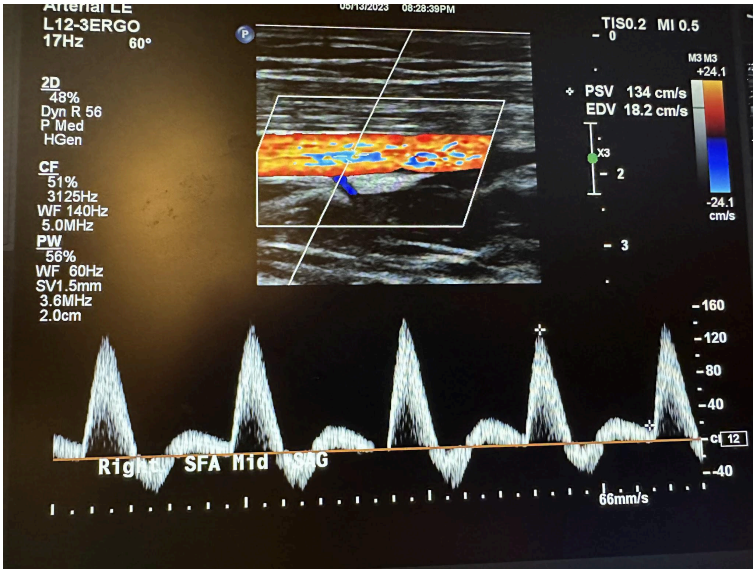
Sagittal image of the right middle superficial femoral artery with color Doppler and waveform analysis.
